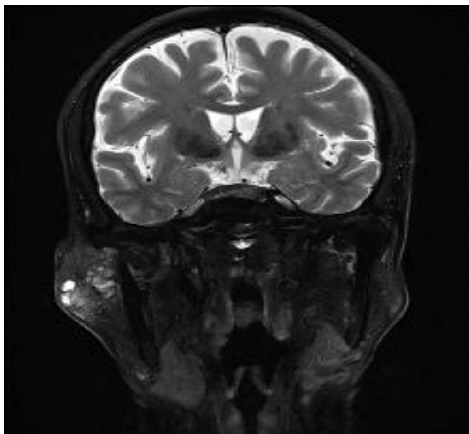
Facial MRI scan showing a tumor with irregular margin in right preauricular area.
